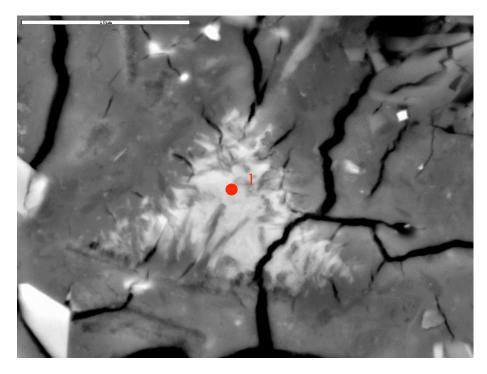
X-ray maps of Fluorite in sample TIND 1-2.
